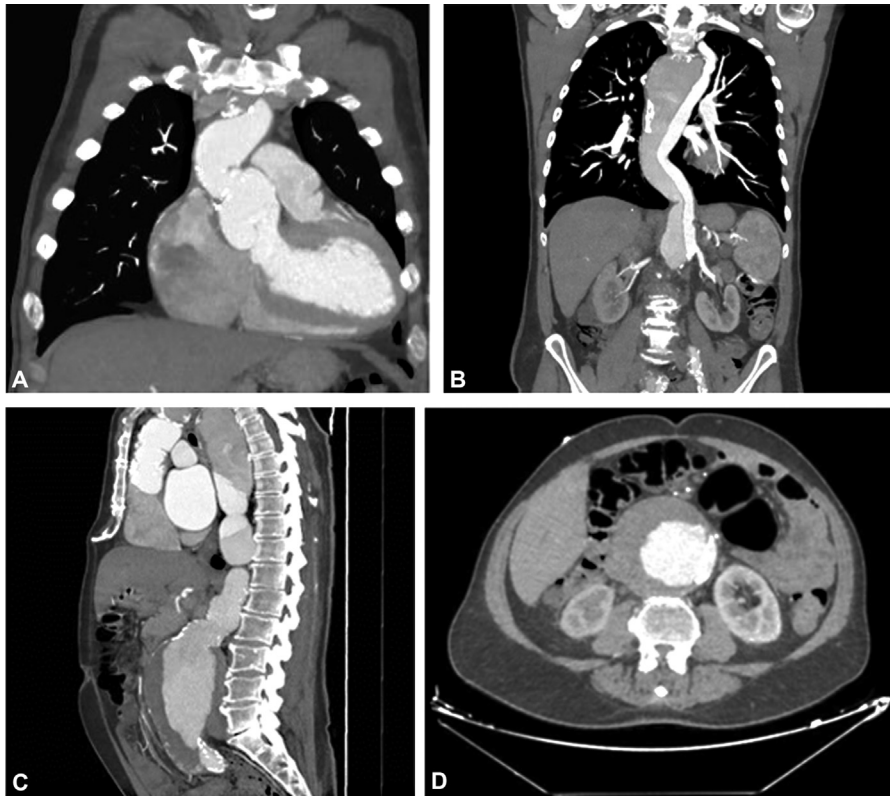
Computed tomography angiography of the aorta. (A) Aortic root dilatation at sinuses of Valsalva (64 mm). (B, C) Correct proximal insertion of the graft and a persistence of a false lumen extending from the distal graft anastomosis to the right iliac artery with aneurysmal dilation at the abdominal site of 12 cm in diameter. (D) Concentric thrombotic apposition of the false lumen.
